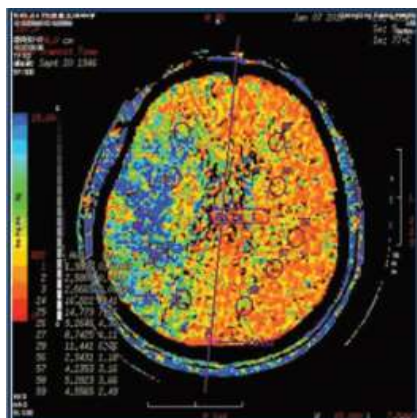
Brain perfusion computed tomograph showed hemisphere hypoperfusion due to ipsilateral severe right carotid stenosis
